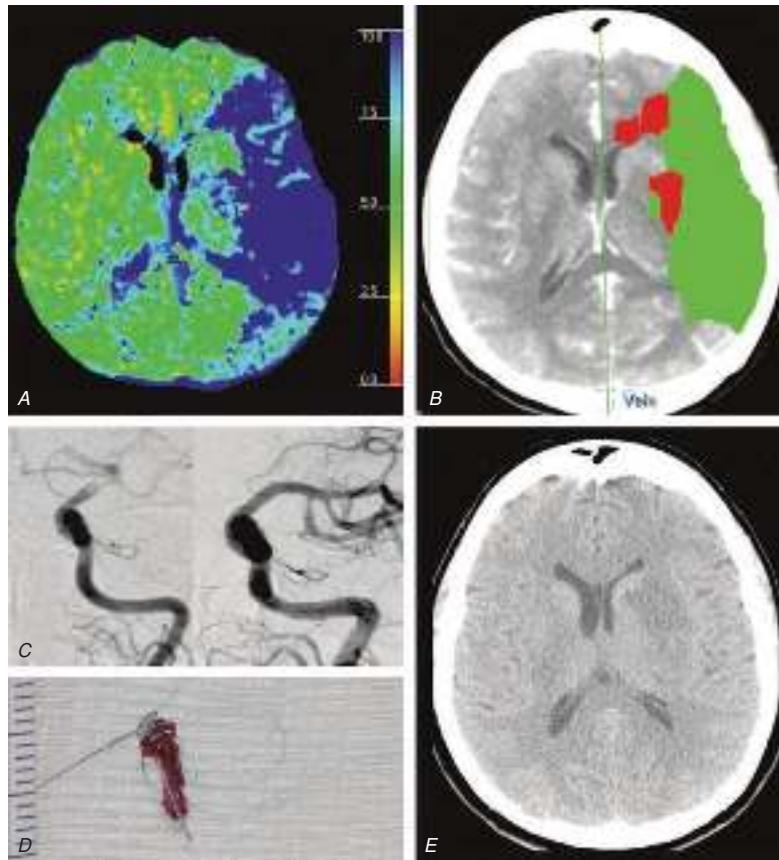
Acute left middle cerebral artery (MCA) stroke with right hemiplegia but preserved language. *A*, Computed tomography (CT) perfusion mean-transit time map showing delayed perfusion of the left MCA distribution (blue). *B*, Predicted region of infarct (red) and penumbra (green) based on CT perfusion data. *C*, Conventional angiogram showing occlusion of the left internal carotid–MCA bifurcation (*left panel*), and revascularization of the vessels following successful thrombectomy 8 h after stroke symptom onset (*right panel*). *D*, The clot removed with a thrombectomy device (L5, Concentric Medical, Inc.). *E*, CT scan of the brain 2 days later; note infarction in the region predicted in *B* but preservation of the penumbral region by successful revascularization.
